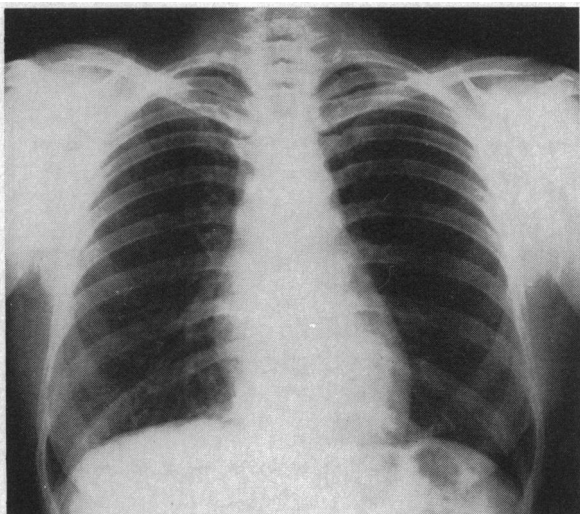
Roentgenogram of the chest two months after completion of initial course of radiation therapy, showing complete regression of the mediastinal mass.
